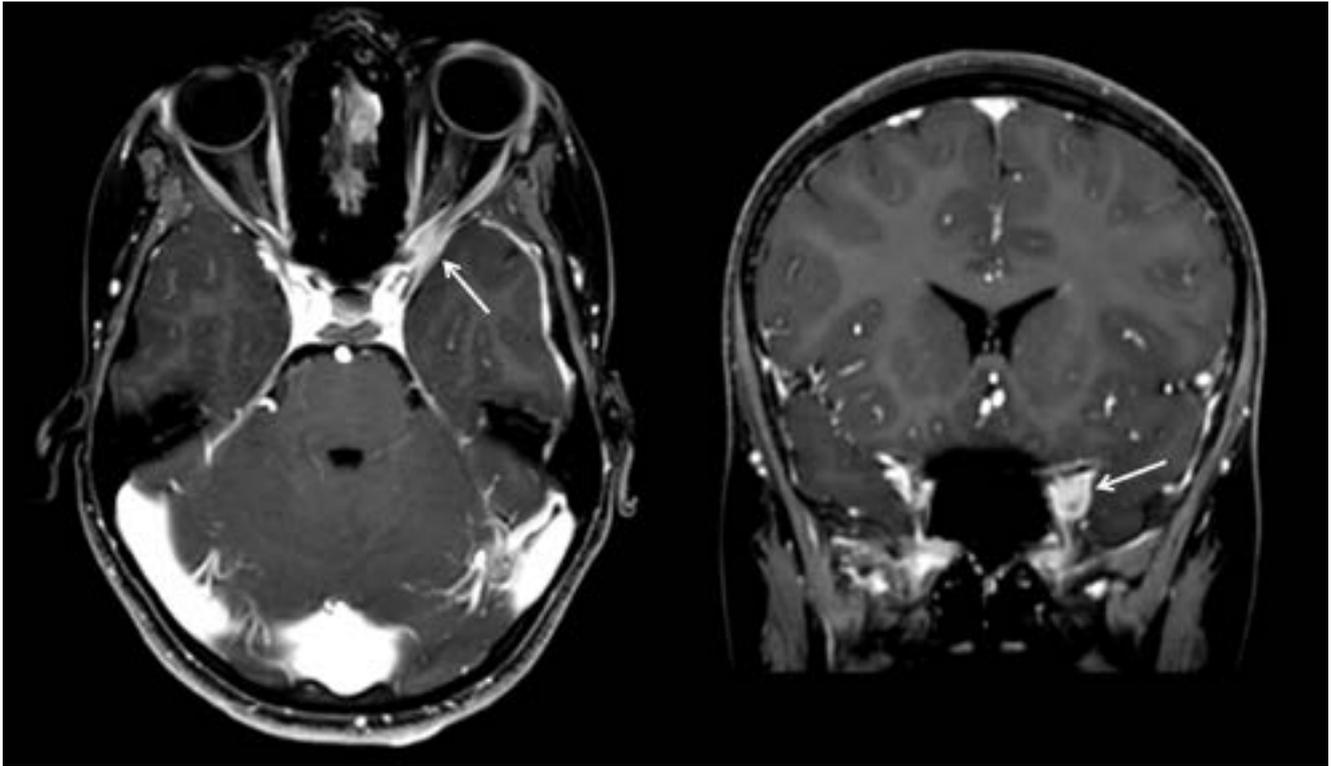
T1-weighted images with contrast (Gadolinium), note the contrast enhancing lesion at the left orbital apex (arrow)
